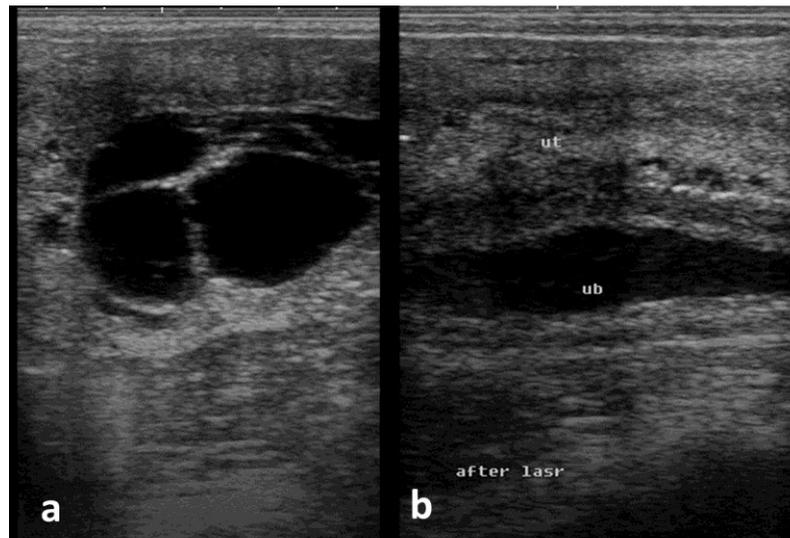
Ultrasonography of three endometrial cysts in a 15-year-old Straight Egyptian Arabian mare before (a) and after laser cyst ablation (b).
